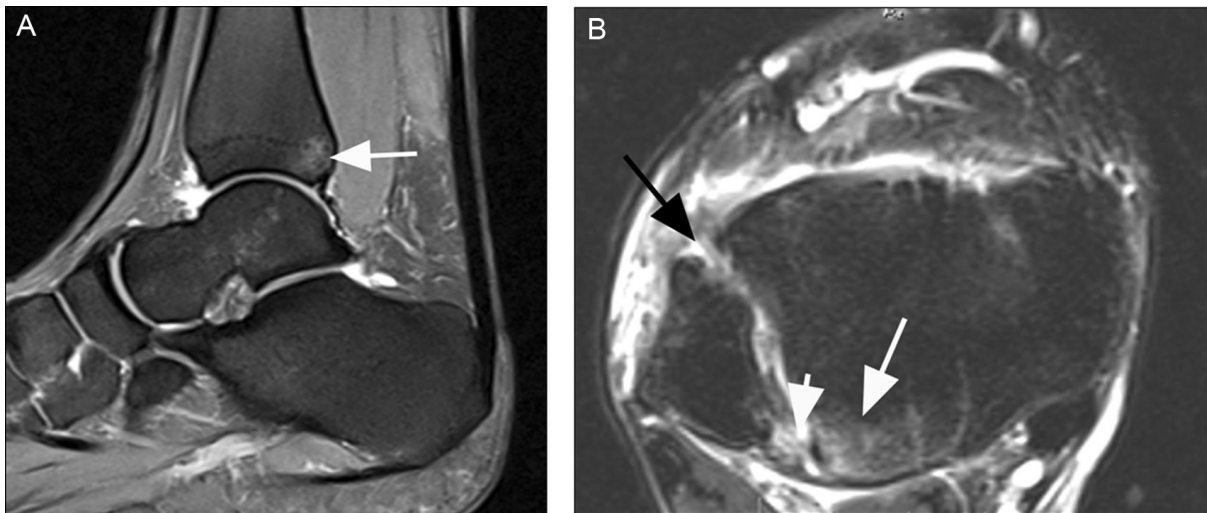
A 22-year-old male football player with acute ankle sprain. (A) Sagittal proton density-weighted fat-suppressed MRI shows an avulsion oedema at the posterior periarticular tibia near the attachment of the posterior inferior tibio-fibular ligament (arrow). (B) Axial proton density-weighted fat-suppressed MRI shows interstitial oedema of the ligament itself (short white arrow). Injury to the posterior syndesmosis always involves the posterior aspect of the tibia (long white arrow). In addition there is a complete tear of the anterior syndesmotomic ligament (black arrow) and surrounding oedema. Consecutive scarring of the posterior syndesmosis may lead to posterior impingement syndrome.
